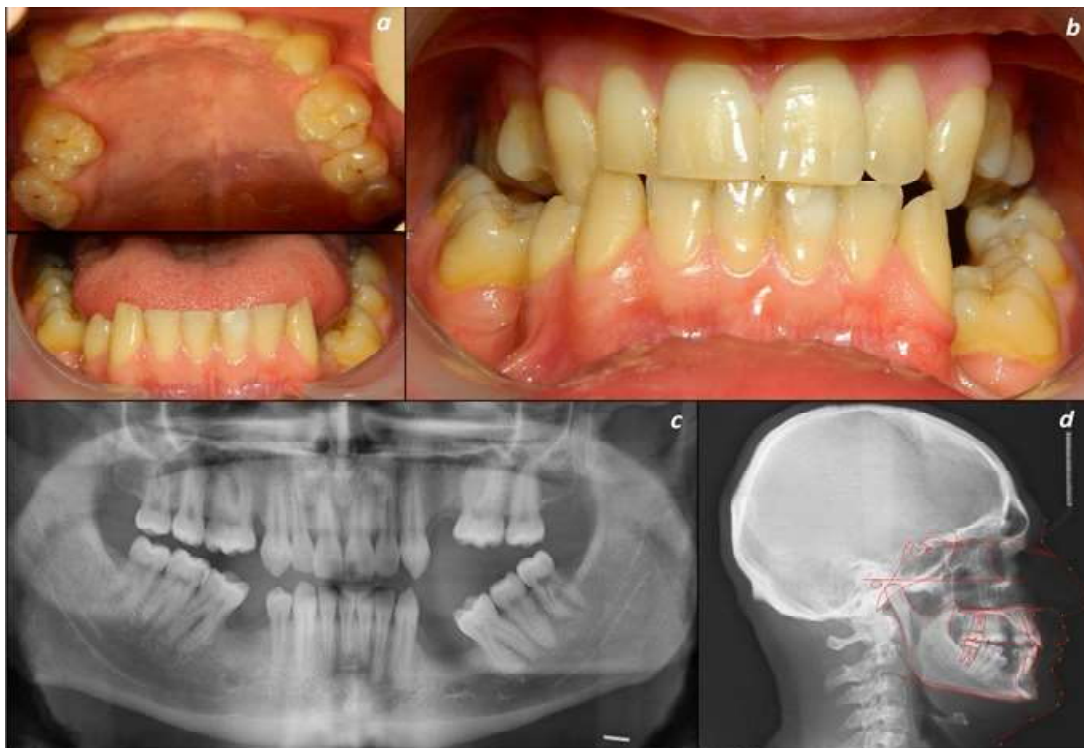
a; clinical views of patients after 15 years. b; Bilaterally, molar open-bite was detected and an orthodontic treatment with orthodontic Surgery c; Orthopantomographic view of the patient after 15 years. d; Cephalometric analyses have been repeated and SNA (90°), SNB ($87,3^\circ$) and ANB ($2,8^\circ$) angles were measured.
